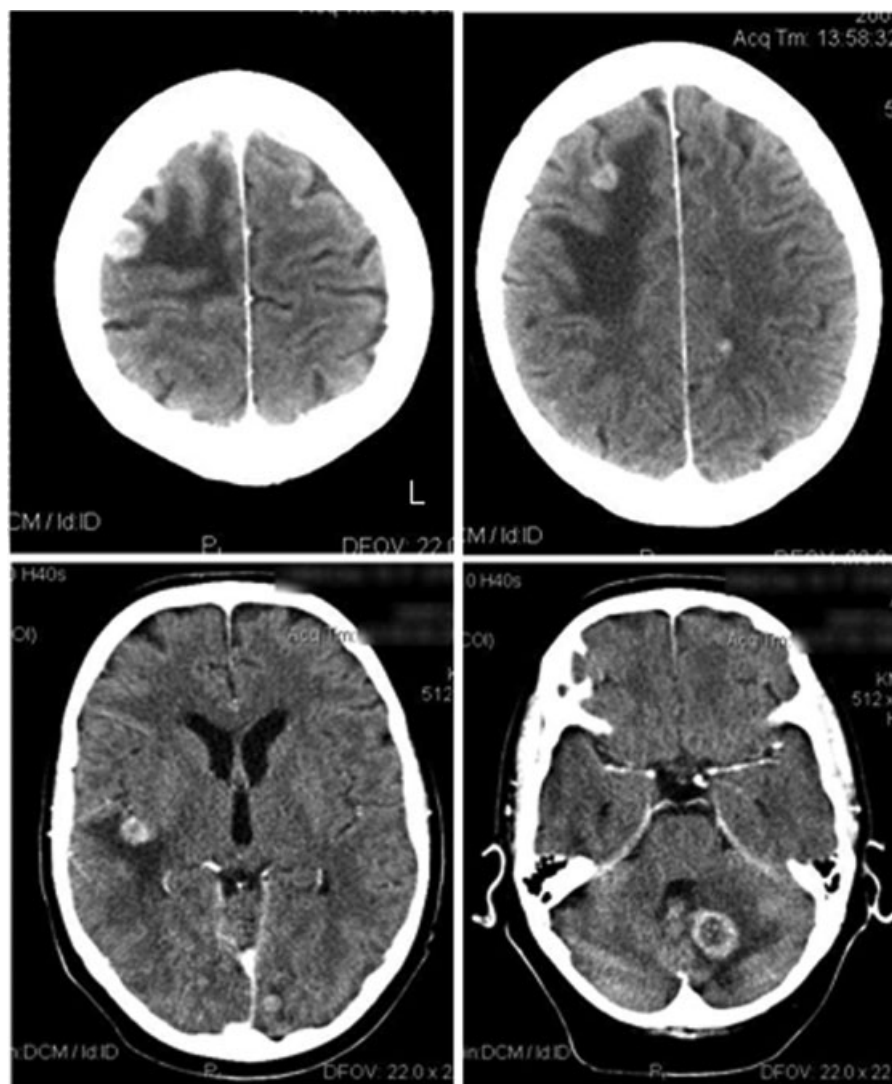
Computed tomography of the head after contrast medium administration. The soft tissue window shows multiple intracranial contrast-enhancing lesions suggestive of multiple cerebral metastases from the patient's known bronchial cancer.
